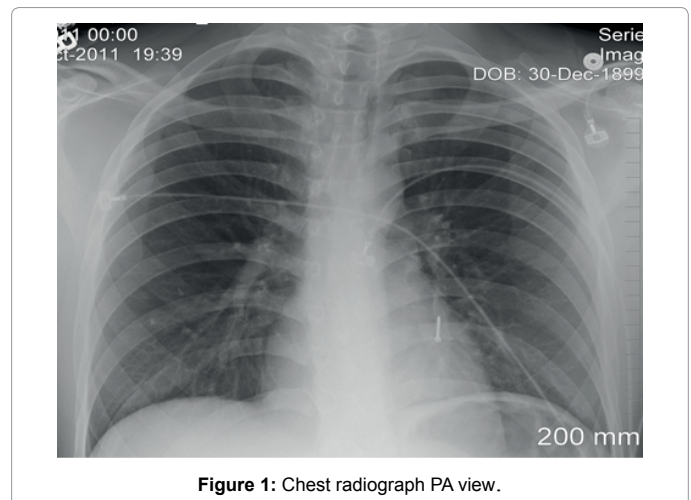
Chest radiograph PA view.
